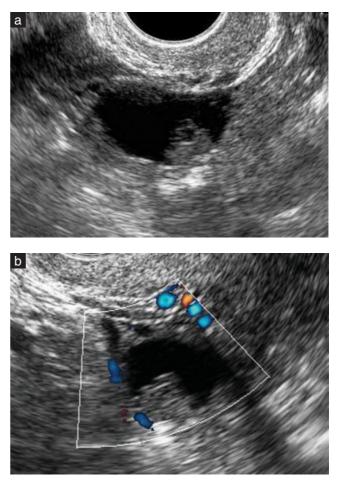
Ultrasound images showing benign serous cystadenoma: (a) gray-scale image showing small cyst with internal papilla; (b) power Doppler imaging did not show internal vascularization of the papilla.
